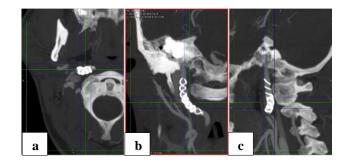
Brain angiography CT scan at six-month follow up using (a) axial, (b) coronal, and (c) sagital view showed successfully treated extracranial right internal carotid artery dissection with hyperdense stents and flow-diverters.
